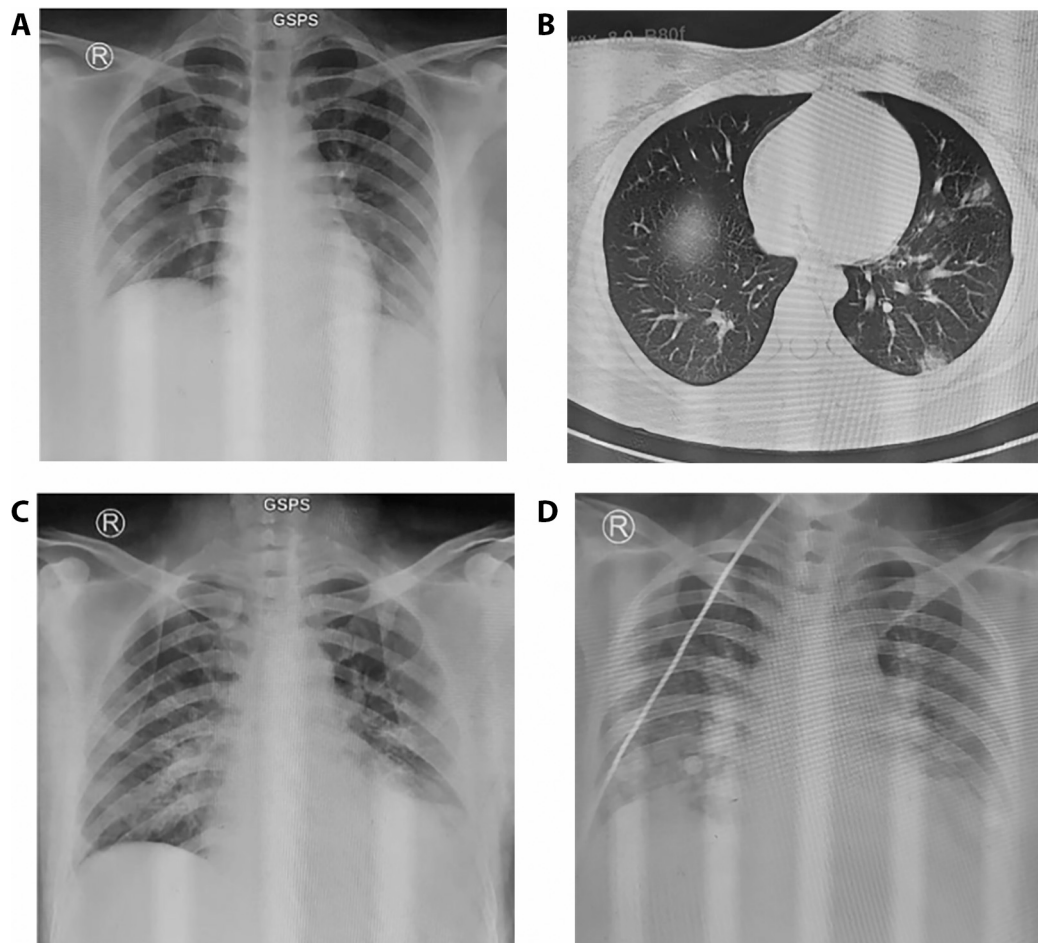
Chest X-ray of Case 1 was normal (A). Chest CT scan of case 1 showed ground glass opacity (GGO) in bilateral lower lungs (B). Chest X-ray of case 2 showed left pleural effusion and infiltrates in bilateral lower lungs (C). Chest X-ray of case 3 showed left pleural effusion and infiltrates bilaterally perihilar and paracardial (D).
